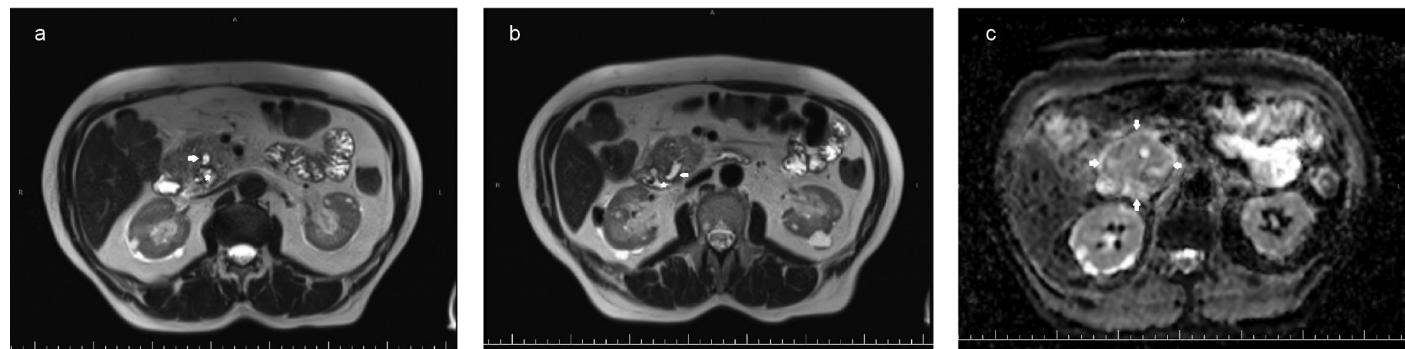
a-c. Magnetic resonance imaging scans of the patient. a) Axial plane T2-weighted image shows the dilated main pancreatic duct (white arrow) passing through the pancreatic mass and abuts a pancreatic pseudocyst (white star). b) More caudal axial plane T2-weighted image shows the dilated main pancreatic duct (white arrow) opens on the papilla (white star). c) Apparent diffusion coefficient (ADC) image shows the mass with no diffusion restriction (white arrows).
